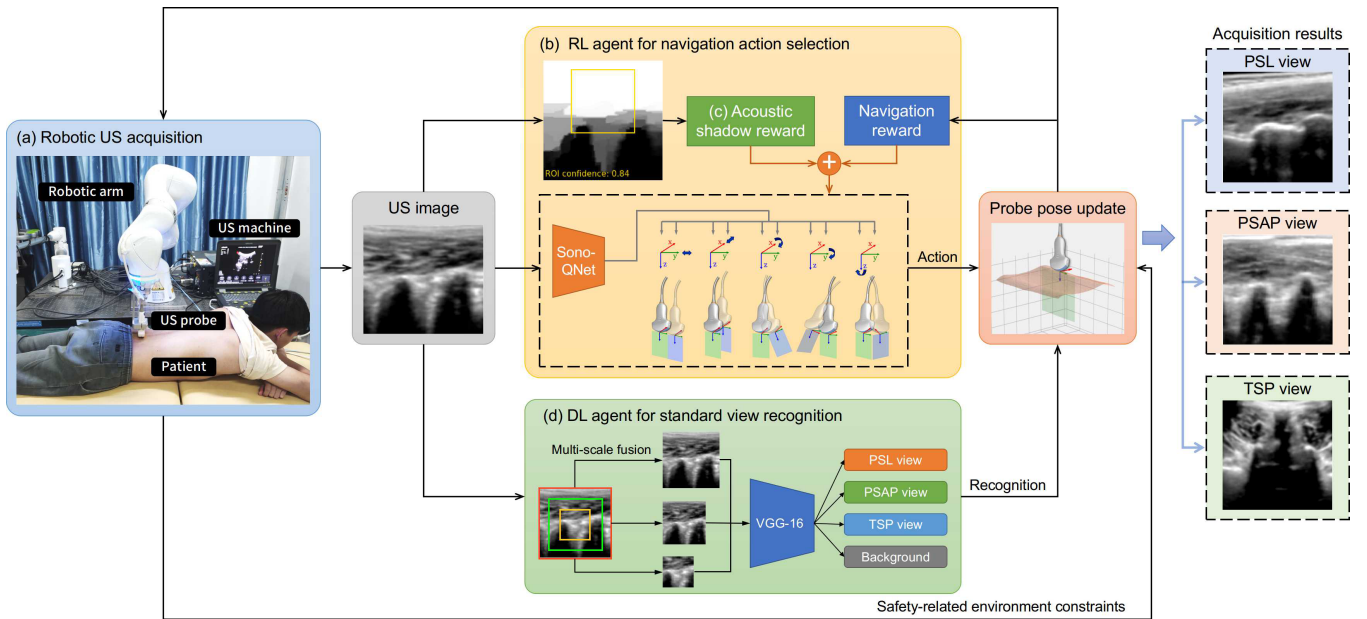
Overview of the presented method for autonomous standard view acquisition in robotic spinal sonography. (a) shows the real-world system configuration, where a US probe is controlled by a robotic arm to scan the patient in the prone position. (b) Given the acquired US image as input, the RL agent selects the best navigation action based on the *SonoQNet* to control the 5-DOF movement of the probe. The US confidence map is computed from the US image to calculate the (c) view-specific acoustic shadow reward, which is used in combination with the navigation reward to train the RL agent. Meanwhile, (d) a pre-trained DL agent recognizes the standard views from the US image and jointly determines the movement of the probe under the safety-related environment constraints. The objective of the proposed framework is to automatically acquire three standard views of the lumbar spine (PSL, PSAP and TSP views).
